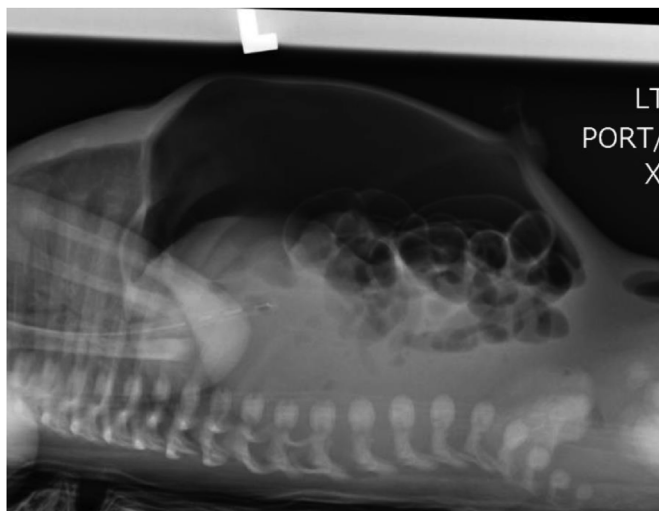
Cross table x-ray view of the abdomen showed a marked distention of the abdomen with a significant degree of free intraperitoneal air throughout. Bowel loops were compressed into the posterior lower abdomen on this film. X-ray findings were compatible with free intraperitoneal air.
